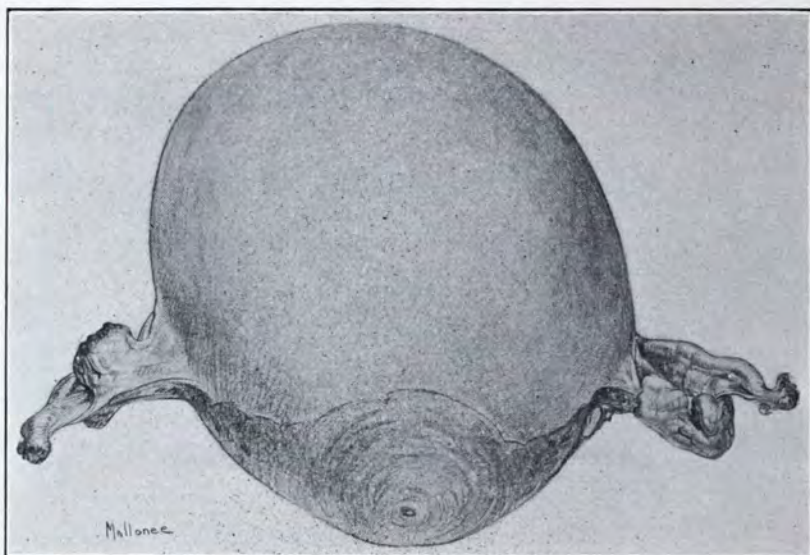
HARD, SCLEROTIC OVARIES, WITH DEEP FURROWS FROM SHRINKING FOLLOWING INTENSIVE TREATMENT WITH X-RAY. The uterus was occupied by a solitary large submucous myoma (the variety that does not yield to Radiotherapy). Bleeding continued in spite of the treatment, therefore suggesting the true nature of the tumor.
